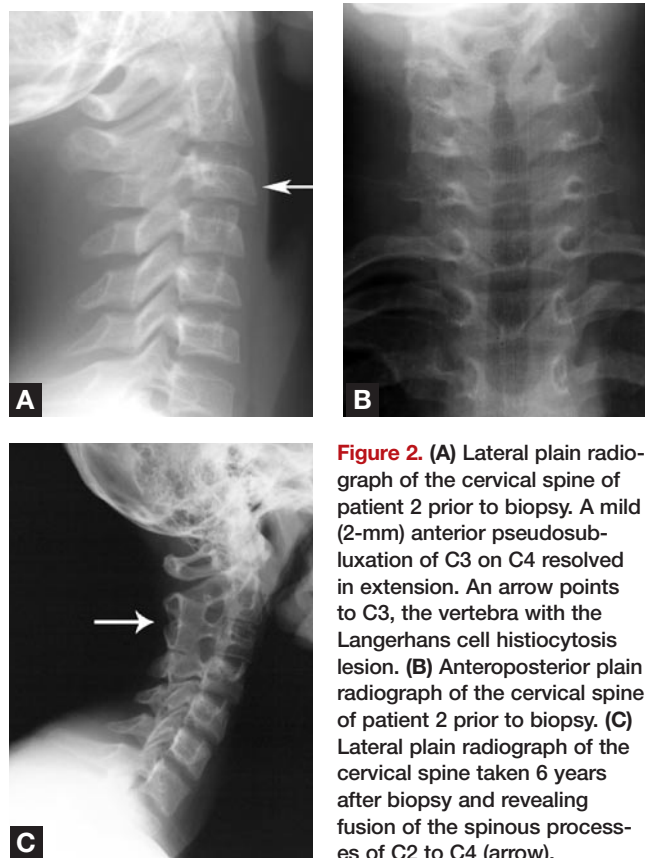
(A) Lateral plain radiograph of the cervical spine of patient 2 prior to biopsy. A mild (2-mm) anterior pseudosubluxation of C3 on C4 resolved in extension. An arrow points to C3, the vertebra with the Langerhans cell histiocytosis lesion. (B) Anteroposterior plain radiograph of the cervical spine of patient 2 prior to biopsy. (C) Lateral plain radiograph of the cervical spine taken 6 years after biopsy and revealing fusion of the spinous processes of C2 to C4 (arrow).
